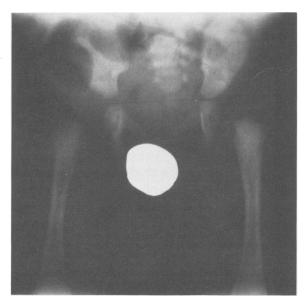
This roentgenogram shows the difficulty in evaluating x-ray studies of the hips in newborns. Although the hips appear symmetric and are not obviously displaced superiorly, there is a suggestion of lateral subluxation bilaterally. The acetabulums appear normal. This infant had positive Barlow and Ortolani signs and was treated with a splint because of the positive clinical findings, in spite of the equivocal x-ray findings. (Reproduced by permission from Specht EE: Am Fam Physician 9:88-96, Feb 74)
